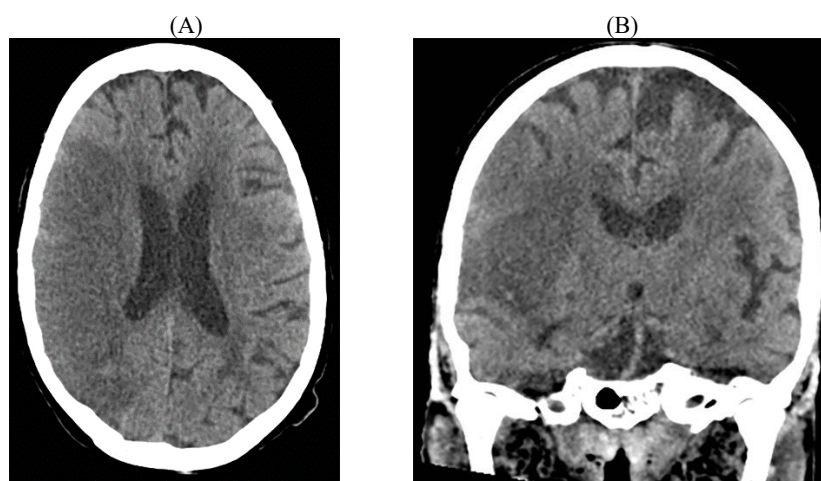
F/75. (A) Transaxial view, (B) Coronal view. The chief complaints of this hypertensive patient were headache and dizziness. Non-contrast brain CT reveals an acute ischemic infarct of the right frontal, temporal, and parietal lobes, equivalent to the right middle cerebral artery territory. The right lateral ventricle is compressed. A dense MCA sign is noted due to the artery thrombotic occlusion at the M2 portion.
